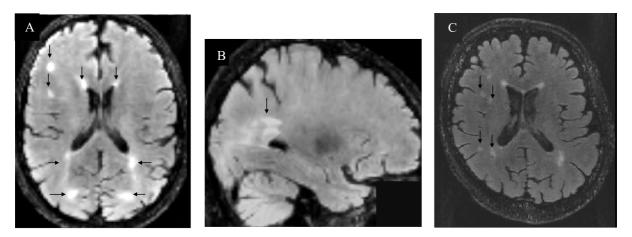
Visual rating of RK's FLAIR imaging.
